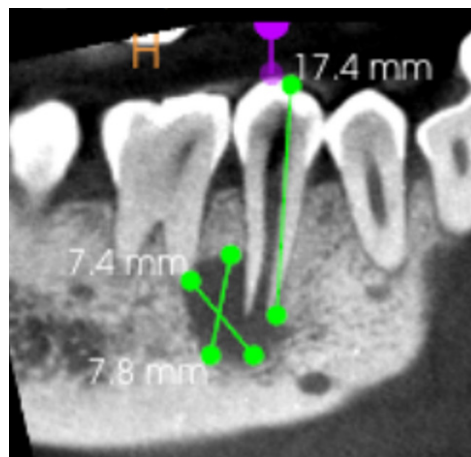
Pre-operative CBCT (Coronal view)
